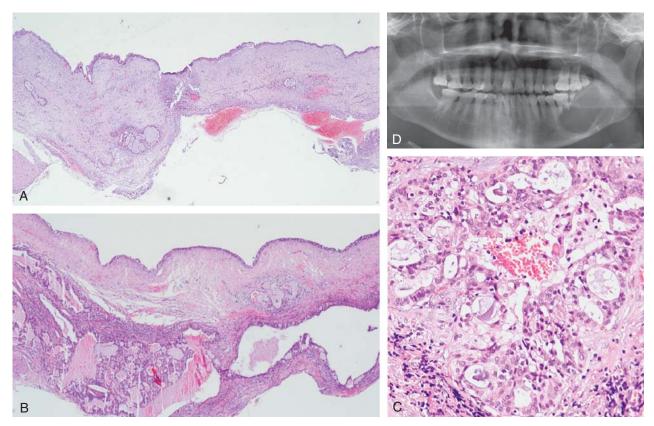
A and B, Jaw cyst with local MEC-like proliferation showing early MEC transformation in case no. 24. C, High-power view showing cystic spaces and epidermoid components composed of mucous-secreting cells, squamous cells, and cells of intermediate type. D, Radiograph showing well-defined unilocular radiolucency in the left mandible.
